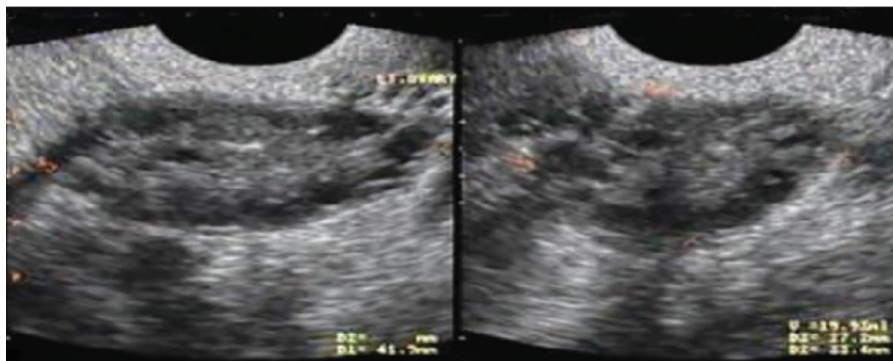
An ultrasound image showing multiple mature follicles (≥ 18 mm) within the ovaries. These follicles would appear as round, dark (anechoic) cysts a (woman 39 years old; the 3rd day of the menstrual cycle)
